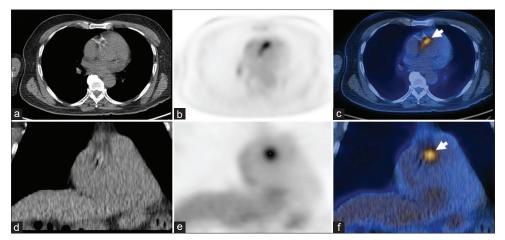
Axial and coronal noncontrast CT (a and d) ¹⁶F-FDG PET (b and e) and fused PET/CT (c and f) images showing increased FDG uptake around the stent in RCA (white arrow). ¹⁶F-FDG PET/CT: 18F-Fluorodeoxyglucose positron emission tomography/computed tomography. RCA: Right coronary artery
